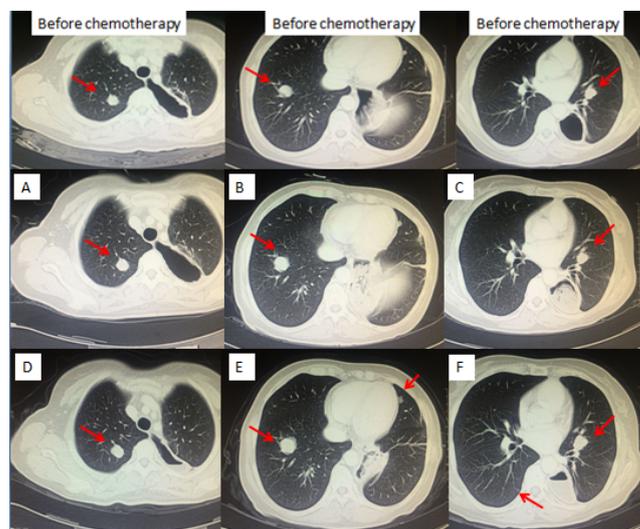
Chest CT scans after chemotherapy. A-C. CT scans were after 2 cycles of first-line chemotherapy (etoposide 100 mg/m² on d 1 to 3 and cisplatin 75 mg/m² on d 1); D-F. CT scans were after 2 cycles of second-line chemotherapy (irinotecan 180 mg/m² on d 1 and raltitrexed 180 mg/m² on d 1). CT scans showed that the metastatic nodules became worse in size and quantity.
